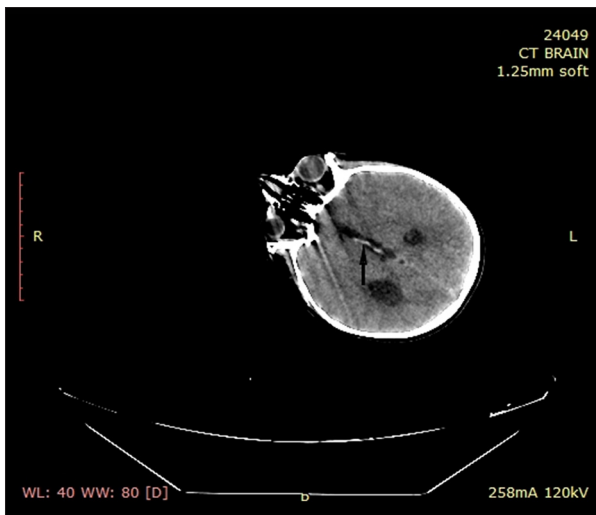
Same CT scan as Figure 1 visualizing a blood clot of adequate dimensions and longitudinally shaped, within the third ventricle. CT – computed tomography.
